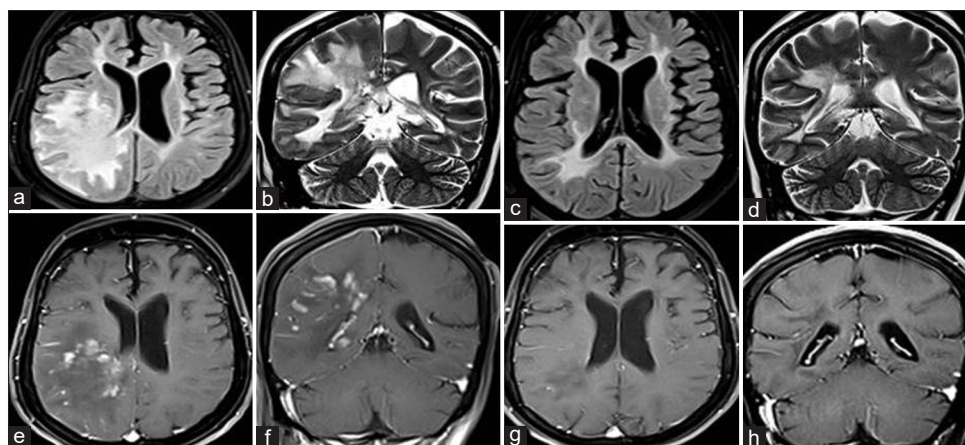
(a) MRI Axial FLAIR and (b) Coronal T2W images showing ill-defined heterogeneous hyperintense lesion involving right temporoparietal white matter with adjacent perilesional edema and mass effect. (e) Postcontrast T1 axial and (f) coronal images showing patchy incomplete ring enhancement pattern. MRI brain 6 weeks after treatment, (c) Axial FLAIR and (d) coronal T2W images showing near-complete resolution of the lesion. (g) Postcontrast T1 axial and (h) coronal images showing no enhancement
